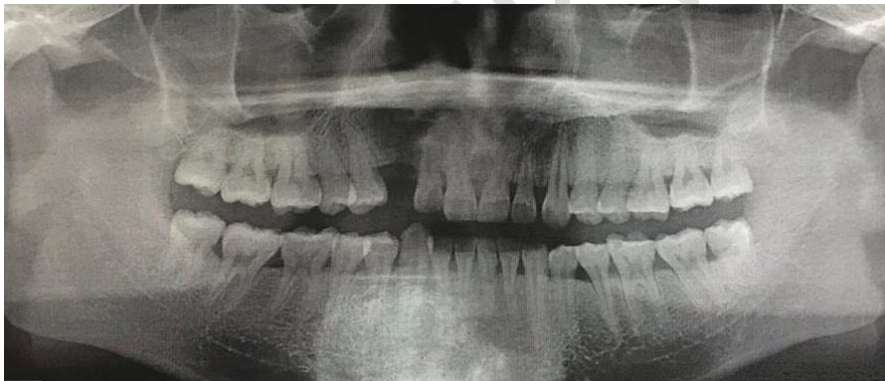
Panoramic view: non demarcated in periapical radiolucent in alveolar region
